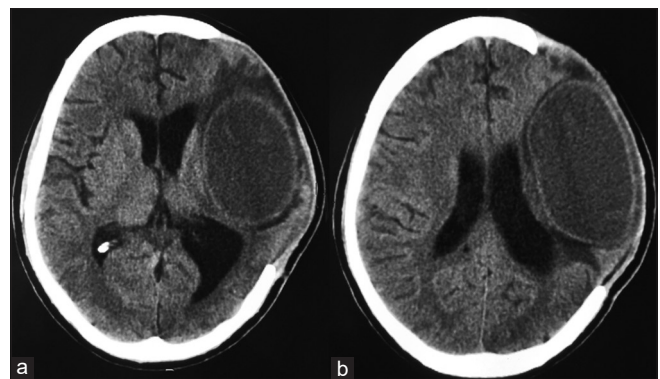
Computed tomography brain plain (a and b) – A well-defined oval-shaped hypodensity (suggestive of brain abscess). Occupying the left fronto-temporo-parietal region. The decompressive bone defect is also visualized
